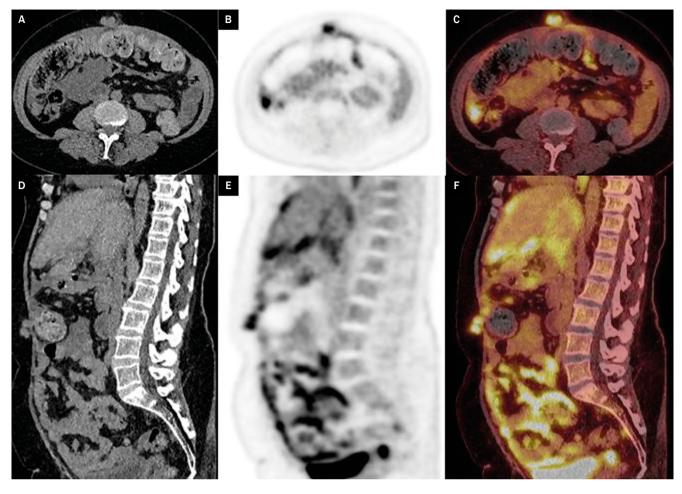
Axial CT (A), [18F]FDG PET (B) and fused [18F]FDG PET/CT (C) and respective sagittal images (D–F) show an avid umbilical eponymously known Sister Mary Joseph nodule (SMJN)
